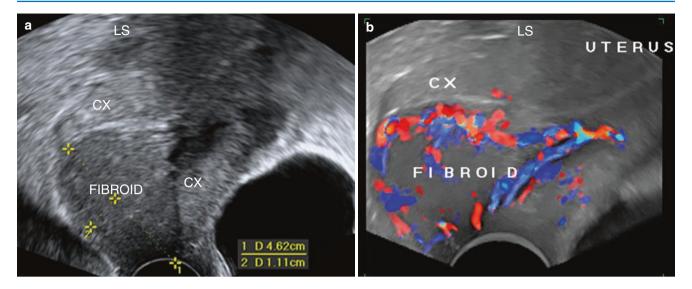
Fibroid polyp. (a) Fibroid protruding out through the cervical os. (b) Its site of origin from the anterior wall of the lower corpus of the uterus is seen on 3D Doppler with glass body display
